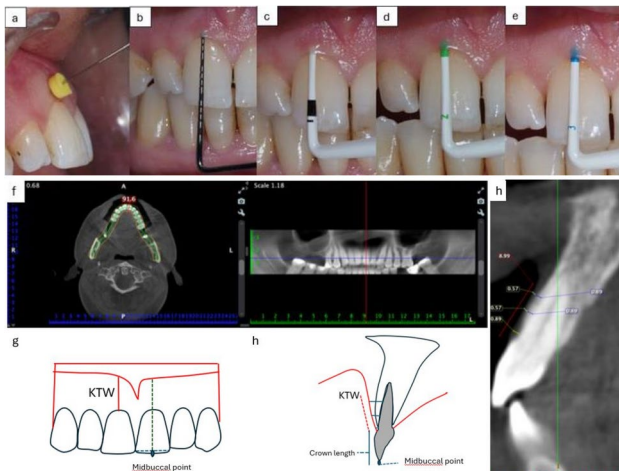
Using an endodontic spreader for measurement with transgingival probing (a), Determining GT with a SPP (b), Determining gingival-thickness with a CPP set (c, d, e), Section passing through the horizontal intersection area perpendicular to the mid-buccal axis of a tooth in the CBCT image (f), KTW measurement (red), gingival-thickness measurement (yellow) and BBT measurement (blue) in the CBCT image (g-h)
